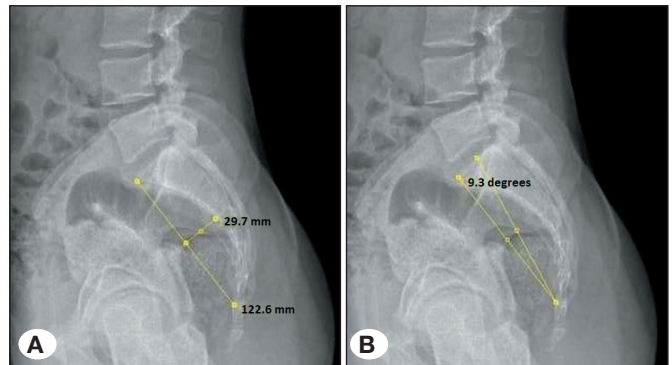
Lateral lumbosacral radiograph of a 20-year-old man with normal alignment of the lumbosacral segments. The measurement of the ATA1 and ATA2 are shown in (A) and (B), respectively.
